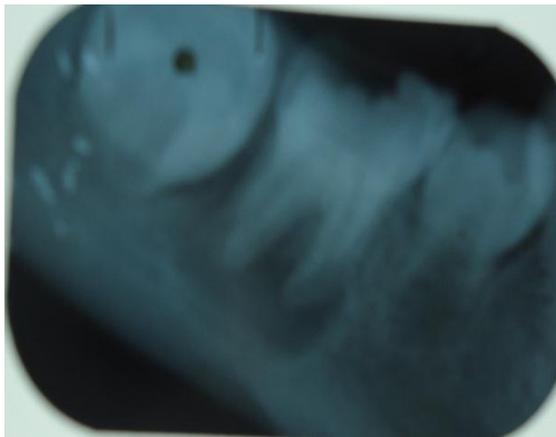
Radiograph of 36 with periapical radiolucency
